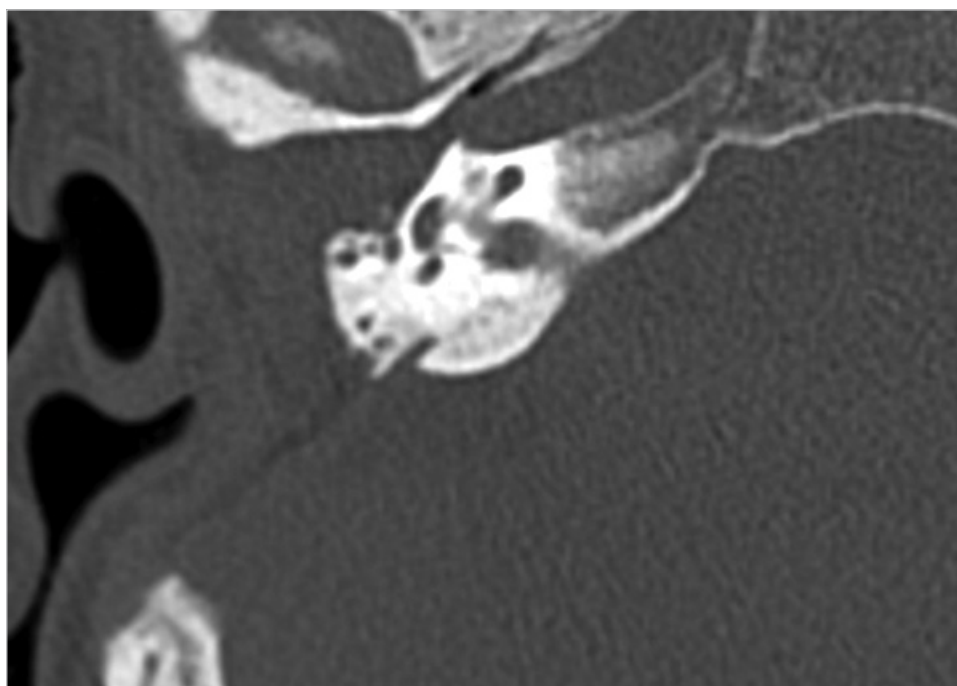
The postoperative CT is shown. The cavity is closed with abdominal fat.
